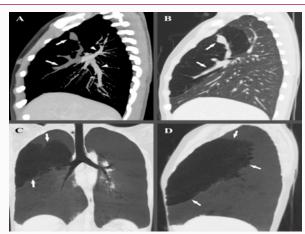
Multiple CT images demonstrating typical CT features of bronchial atresia with mucoid impaction.
